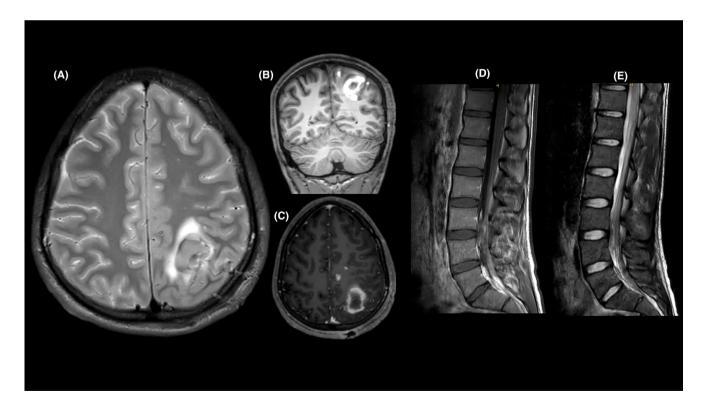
MRI scans of the patient's brain before the evacuation of the largest intracerebral hemorrhage (ICH): An axial FLAIR (A), coronal T1 (B), and axial T1 with contrast (C) show a high parietal T1 peripheral hyperintense/T2 hypo- to isointense lesion ($3 \times 1.8 \times 2.8 \, \text{cm}$) with peripheral edema and without pathological contrast enhancement, compatible with an early subacute (7- to 10 day-old) ICH. MRI scans of the lumbar spine: A T1 scan with contrast (D) and a T2 scan (E) show an intradural T1 hyperintense/T2 hypointense signal alteration at the L3/L4 level, without contrast enhancement, compatible with an early subacute intradural lumbar hematoma.
